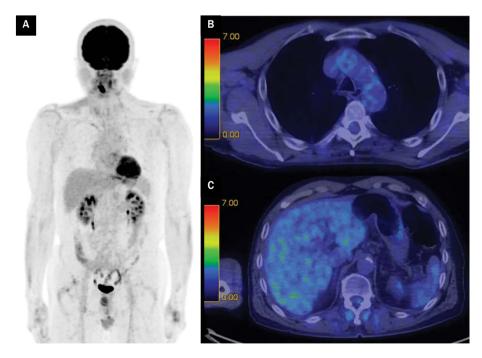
PET/CT image of a representative case with normal renal function. Maximum intensity projection of FDG PET (A), PET/CT fusion image of mediastinal blood pool (B), PET/CT fusion image of liver (C) of a 60-year-old male patient with normal renal function (eGFR: 79 mL/min/1.73 m²). Parameters of interest were as follows: SUV_{max} of 3.0, SUV_{mean} of 2.1 in liver, SUV_{mean} of 1.6 in mediastinal blood pool
